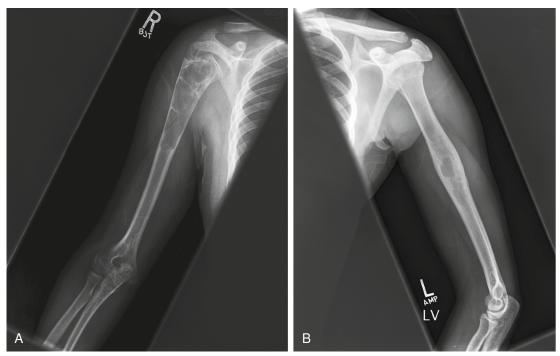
A, Anteroposterior (AP) projection demonstrating multiple well-circumscribed radiolucencies in the proximal humerus consistent with a simple unicameral bone cyst. B, AP humerus radiograph demonstrating a well-circumscribed radiolucency midshaft consistent with a simple unicameral bone cyst. (From The Ohio State University Wexner Medical Center, Columbus, Ohio.)
